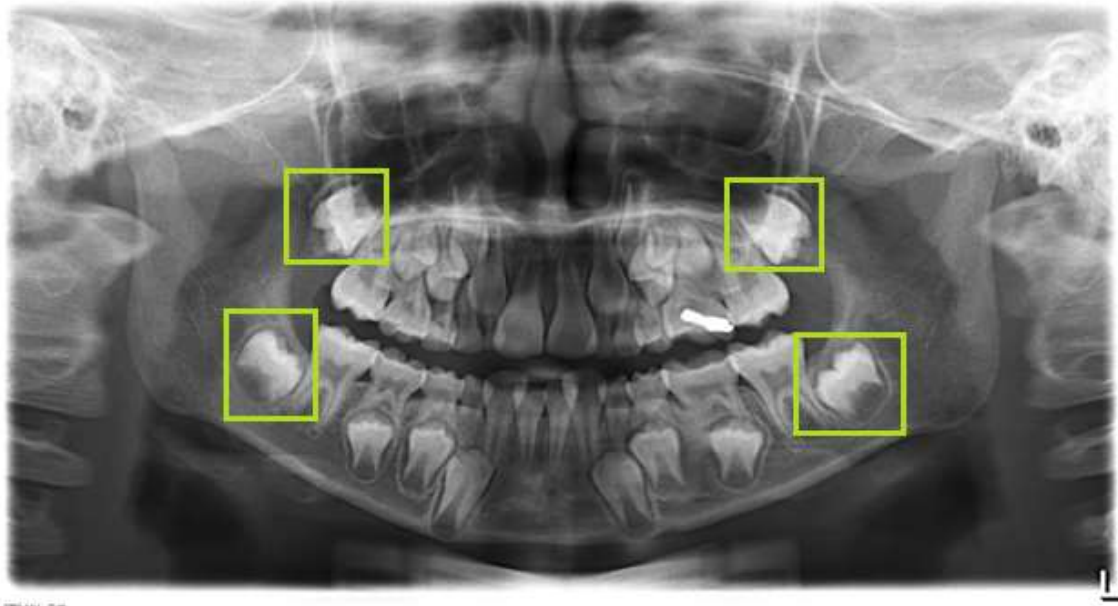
A panoramic radiography dental image
